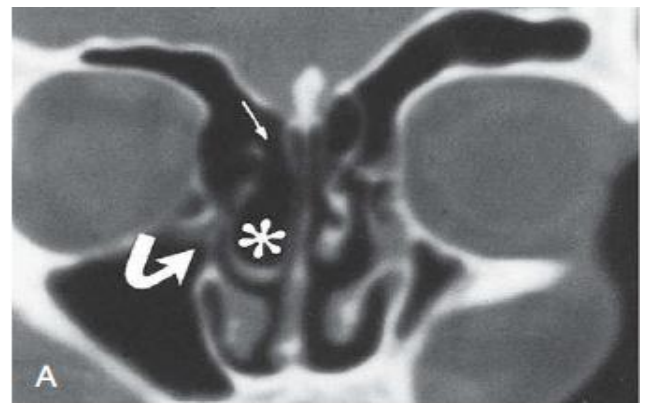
CT scan- Concha bullosa⁽⁷⁾
